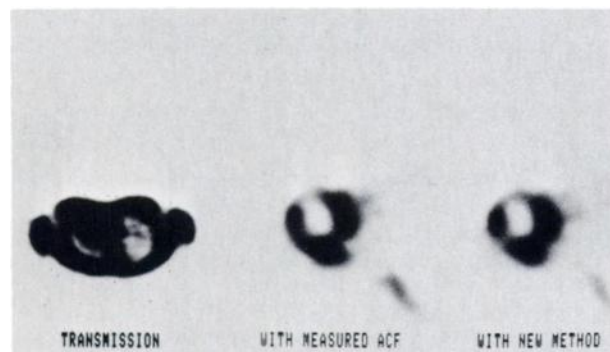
Images of FDG study on patient with extensive myocardial infarction. Left is transmission image (10 M counts). Middle is emission image (1 M counts) by measured ACFs. Right is emission image by boundary method. Similarity between two emission images indicates applicability of boundary method in disease.
